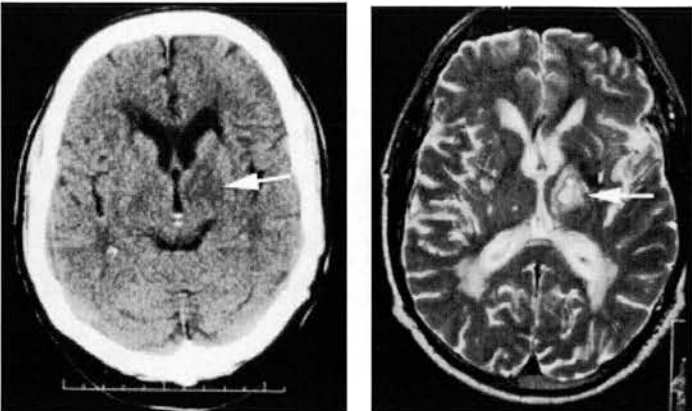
77 year old woman with dysphasia, right homonymous hemianopia, resolved. Scanned 6 days after onset of symptoms. CT on left, gradient echo right.
